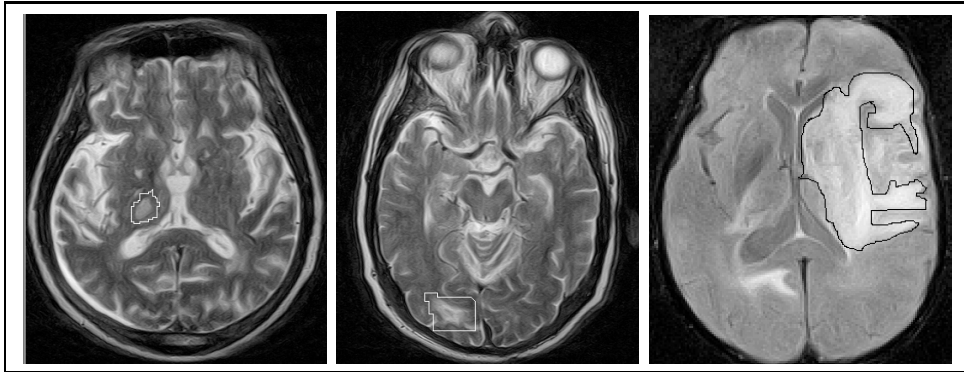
Axial views of three different brains showing lesion. The two left images have been taken in T2 modality and the right one has been taken in FLAIR modality. In each image, the lesion has been marked and is demonstrating how the shape of lesions varies. The lesion in the left image is small and has well-defined edges. The lesion in the middle image has a shape not well-defined and edges are not contrasted. The lesion in the right image occupies a large part of the brain, but edges are not well-defined and their detection is not simple.
